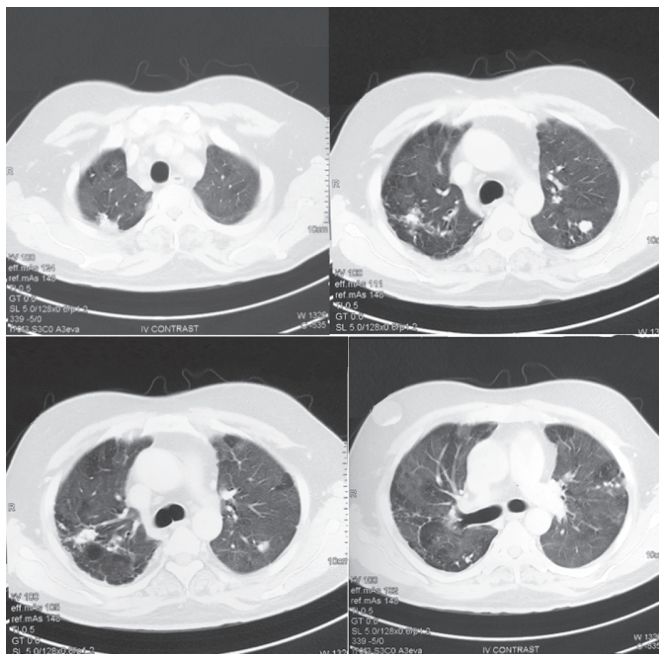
High-resolution computed tomography and contrast-enhanced computed tomography chest done after first discharge showing nodular fibrocalcific opacities, interlobular septal thickening and mosaic attenuation of bilateral lungs suggestive of novel corona virus-induced pneumonia sequelae
